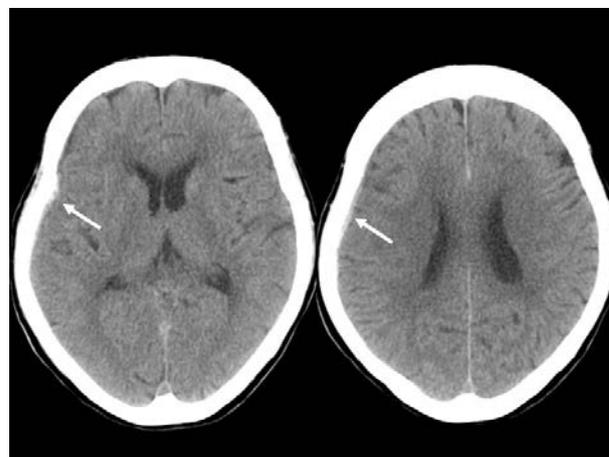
Compute tomography (CT) on arrival. CT showed right, thin ASDH (arrow)
